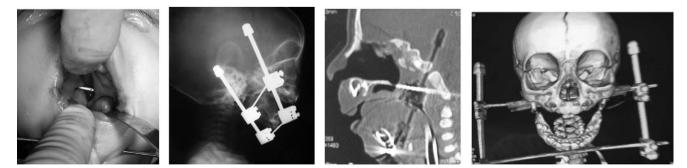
Transfixing Kirschner wires: (a) intraoperative view; (b and c) radiographic views and (d) computer tomography scan.
